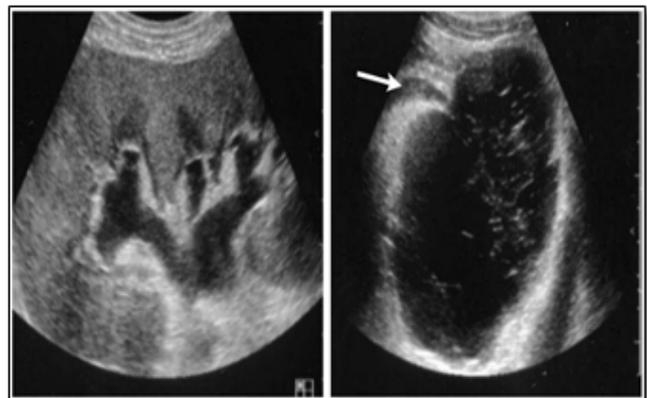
Ultrasound scanning showing dilatation of the pelvi-calyceal system and ureter (arrow) with a large anechoic pelvic collection [9].
